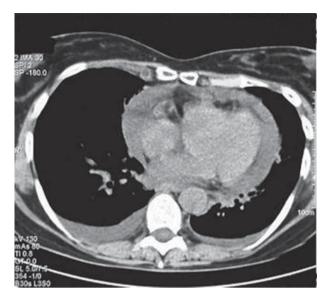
Chest CT scan in which the pericardial effusion is revealed.
